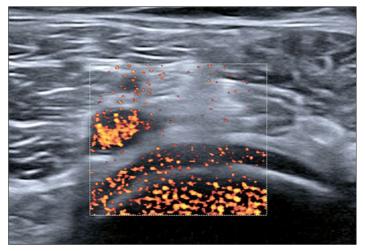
The color Doppler may reveal the nerve adjacent or above the tibial artery.
